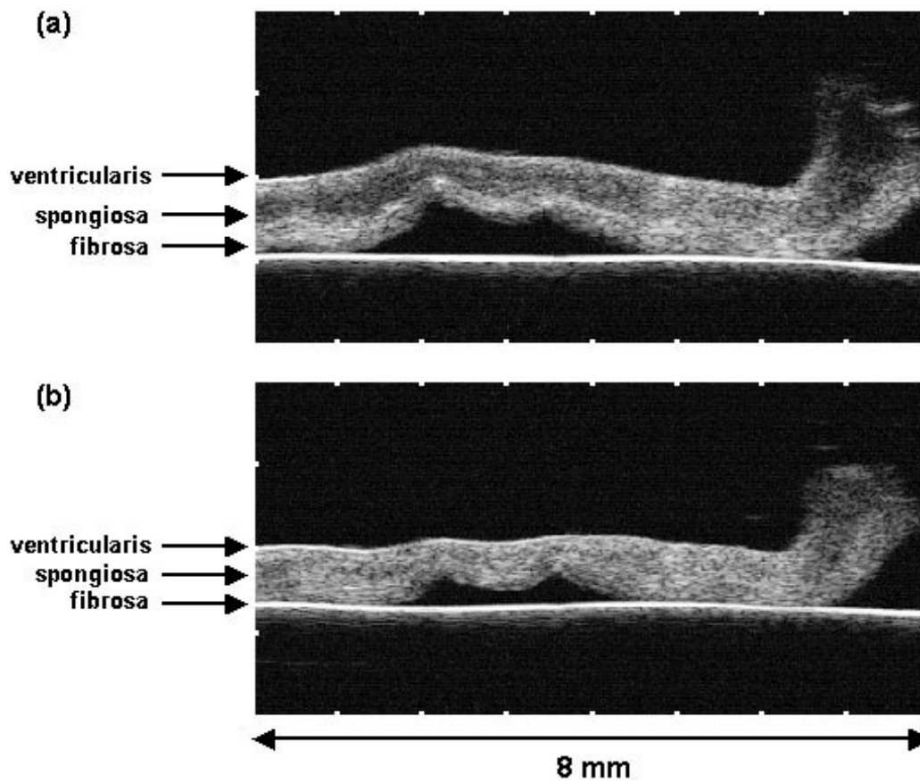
Ultrasound images of the same cross-sectional plane through valve: (a) cusp imaged while submerged in distilled water; (b) same cusp imaged after submersion in Hanks physiologic solution. Focus on thickness changes depending on hydration level.*
